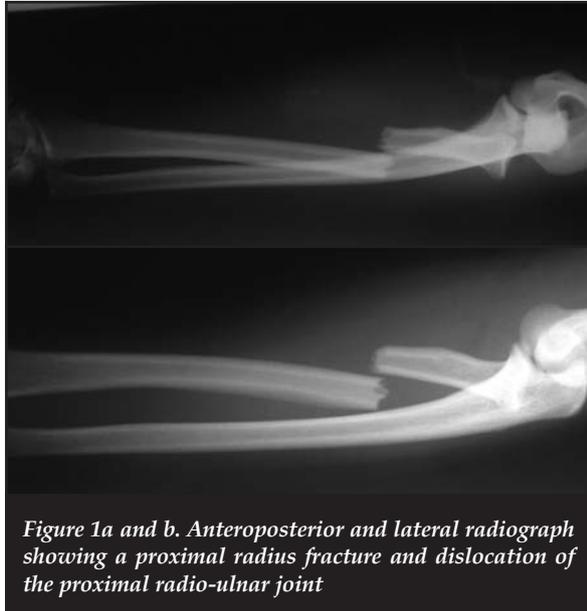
Anteroposterior and lateral radiograph showing a proximal radius fracture and dislocation of the proximal radio-ulnar joint
